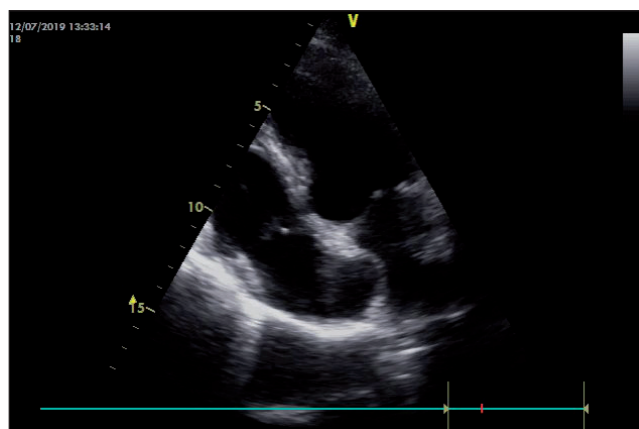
ASA in the 2D transthoracic imaging – apical four chamber view (A4C).
